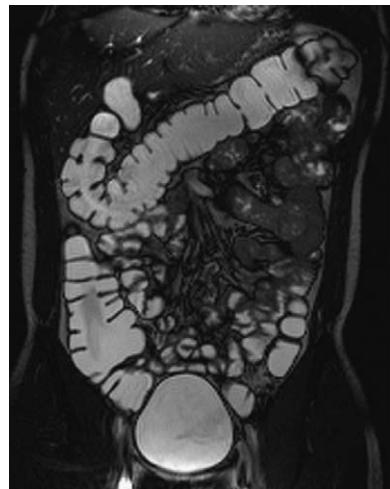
Fast imaging with steady-state precession sequence of the colon. The contrast mechanism is different compared with the T1-weighted images; the colonic lumen is rendered bright, whereas the colonic wall is seen as a dark filling defect.
